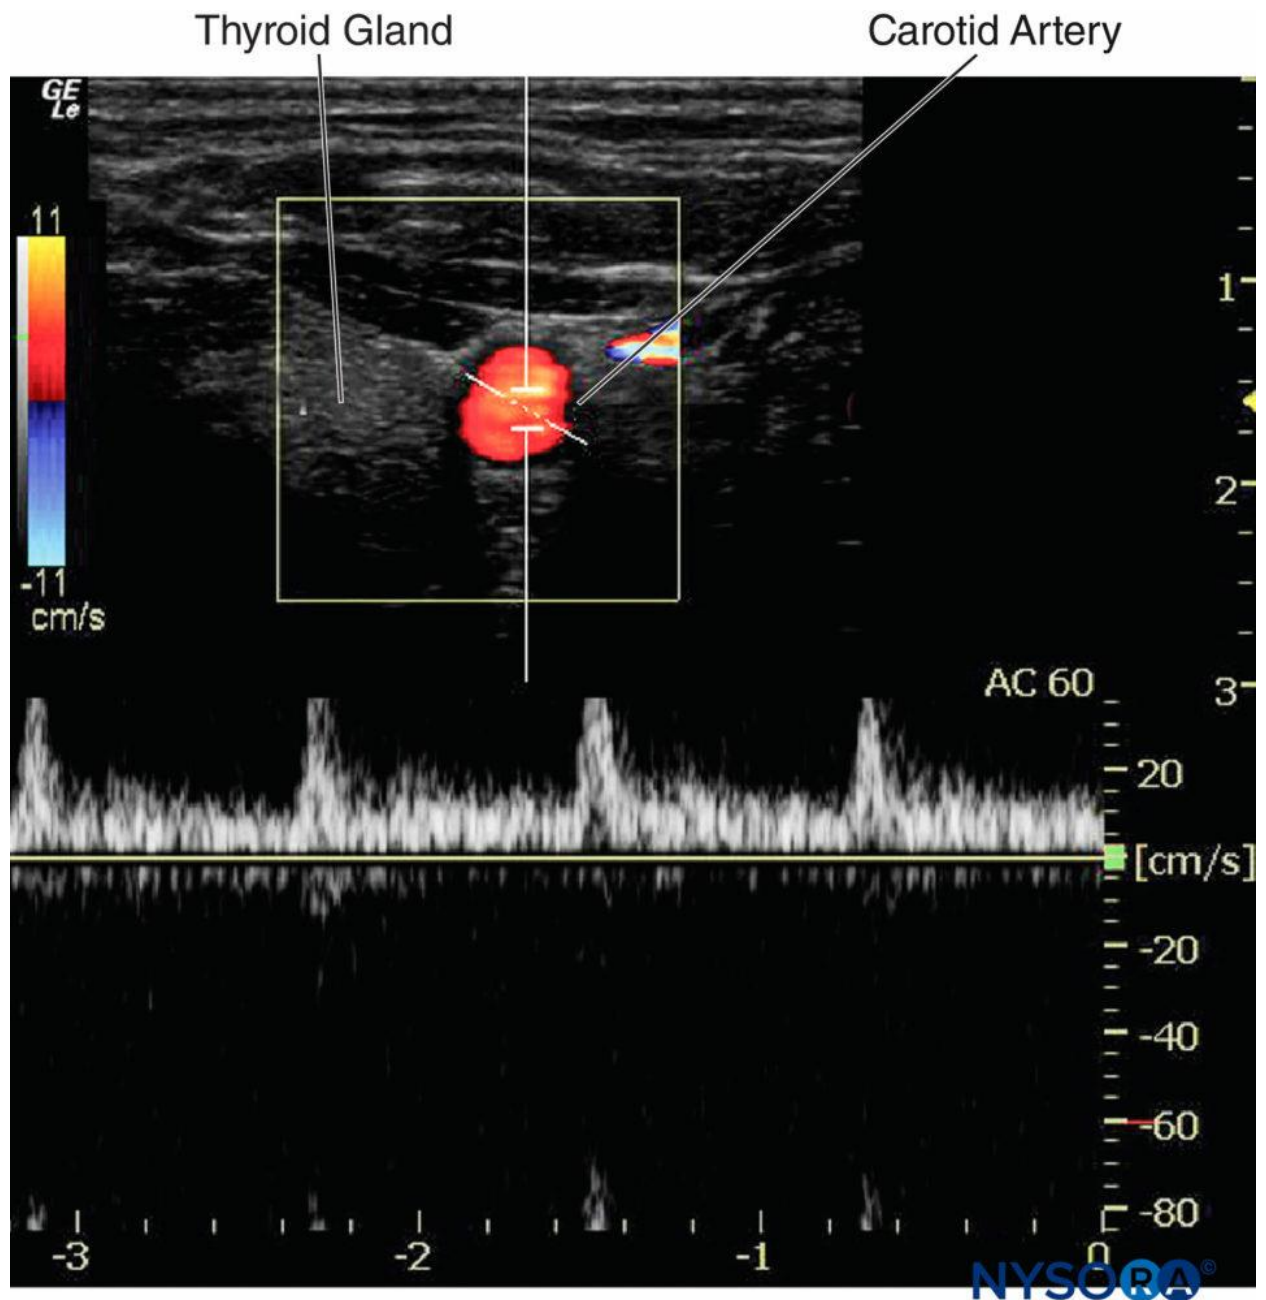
A: Carotid artery displays a red color when the blood flows toward the transducer. B: Carotid artery displays ambiguous color at a 90° Doppler angle; the equal waveform can be seen on both sides of the baseline. C: Carotid artery displays blue color when the blood flows away from the transducer.
